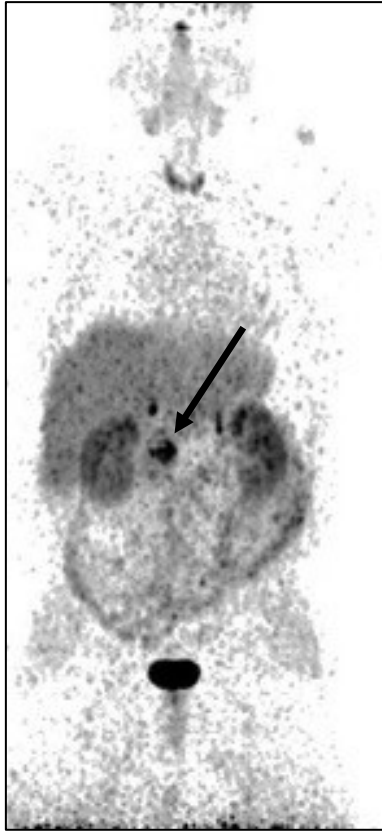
Maximum intensity projection (MIP) of PET/CT with high physiological uptake in the urinary tract and moderate physiological uptake in the pancreatic uncinata process (arrow)
